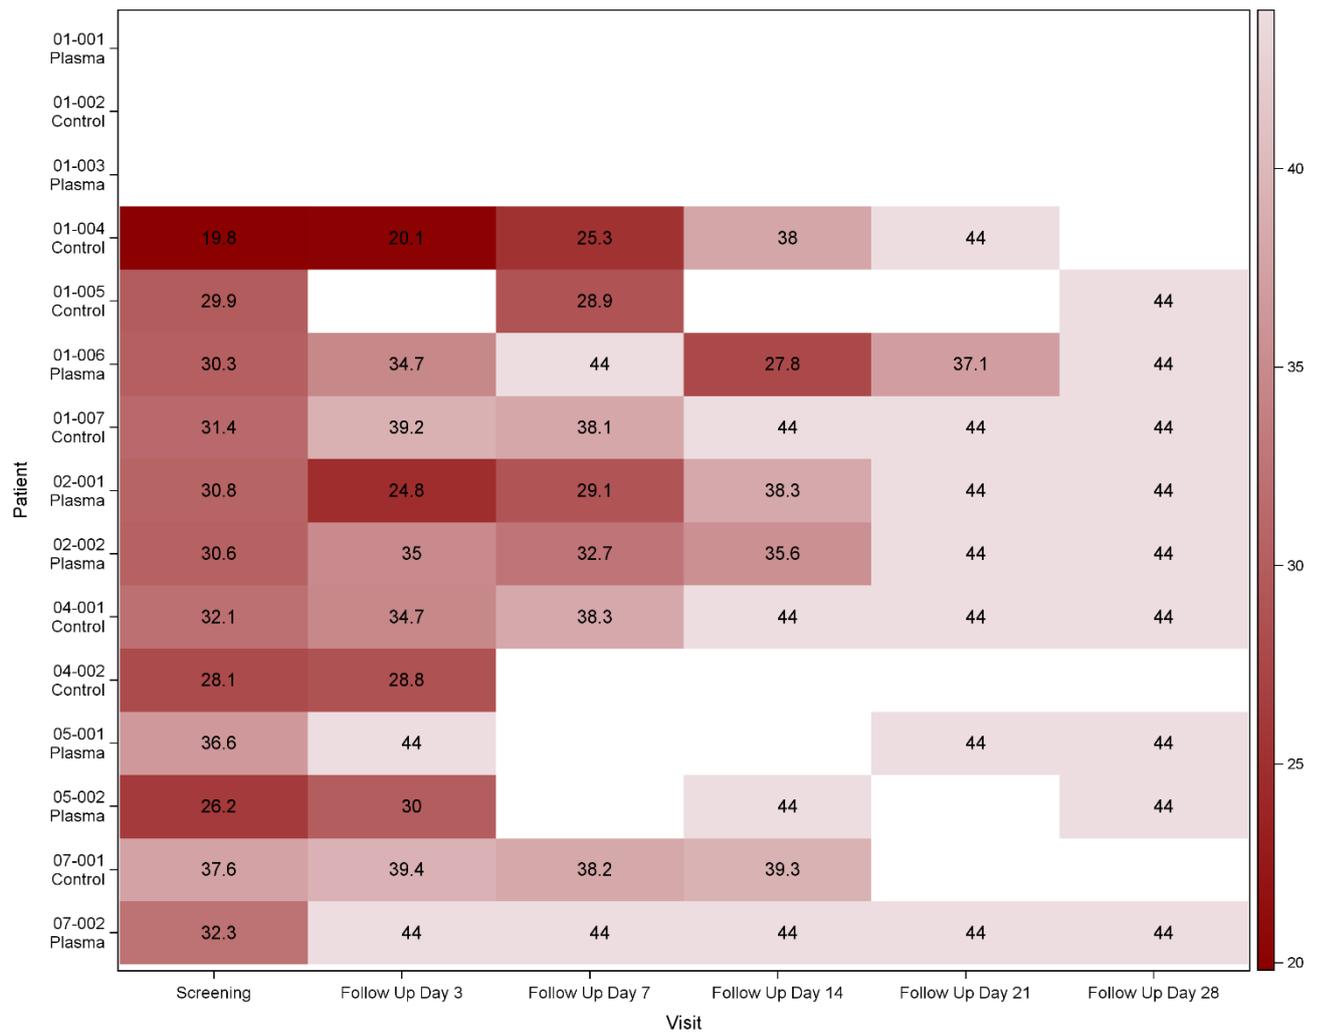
CT values for all patients over all visits. Patients 01-001, 01-002 and 01-003 had no available data. Missing values were not imputed. Negative PCR was imputed with 44 because higher CT values imply lower virus levels.
